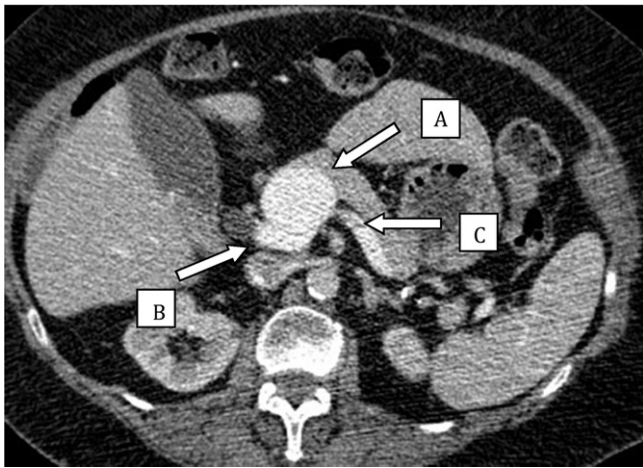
Axial CT shows portal vein aneurysm (A) and the confluence of main PV (B), splenic vein (C).
